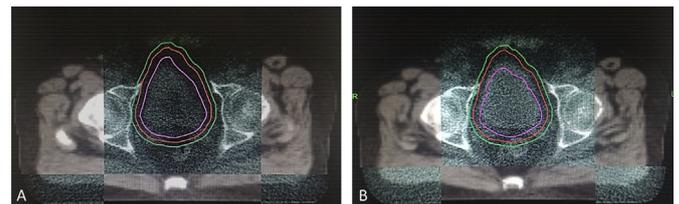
Axial view of on-board megavoltage computed tomography matched with planning computed tomography showing the three planning target volumes (PTVs), with the bladder fitting into the smallest PTV in the first fraction (A) but requiring a larger PTV in the second fraction (B).
